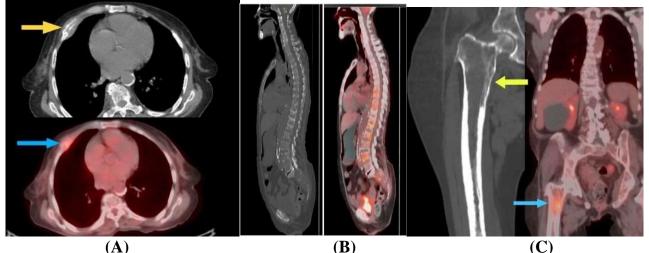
A 73 years old female presented with history of metastatic plasma cell myloma on chemotherapy for follow up. (A):AxialCT& fused PET/CT chestshowright anterior chest wall expansilelesionwithpathological ribfracture(yellowarrow)showing high FDG uptake achieving8.15 SUVmax(bluearrow). (B): Sagittal CT& fused PET/CT spine show generalized decrease bone density associated with compression of multiple lower dorsal and lumbarvertebraewith mixed lytic and sclerotic lesions, no associated soft tissue component, with multilevel metabolically active FDG avid lesions of the spine. (C): Coronal CT&fused PET/CT proximal femur showfocal expansion with bone rarefaction(yellow arrow)with increased FDG uptakeachieving up to 4.05 SUVmax (blue arrow).
